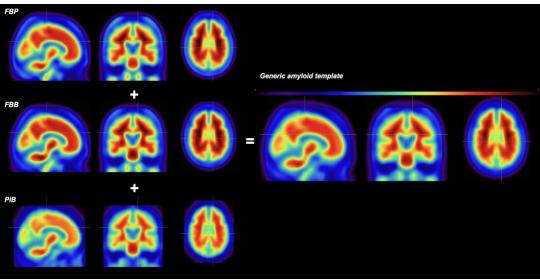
Tracer-specific templates (left) and the resulting generic amyloid template (right). Color bar shows 0-2 SUVR.
